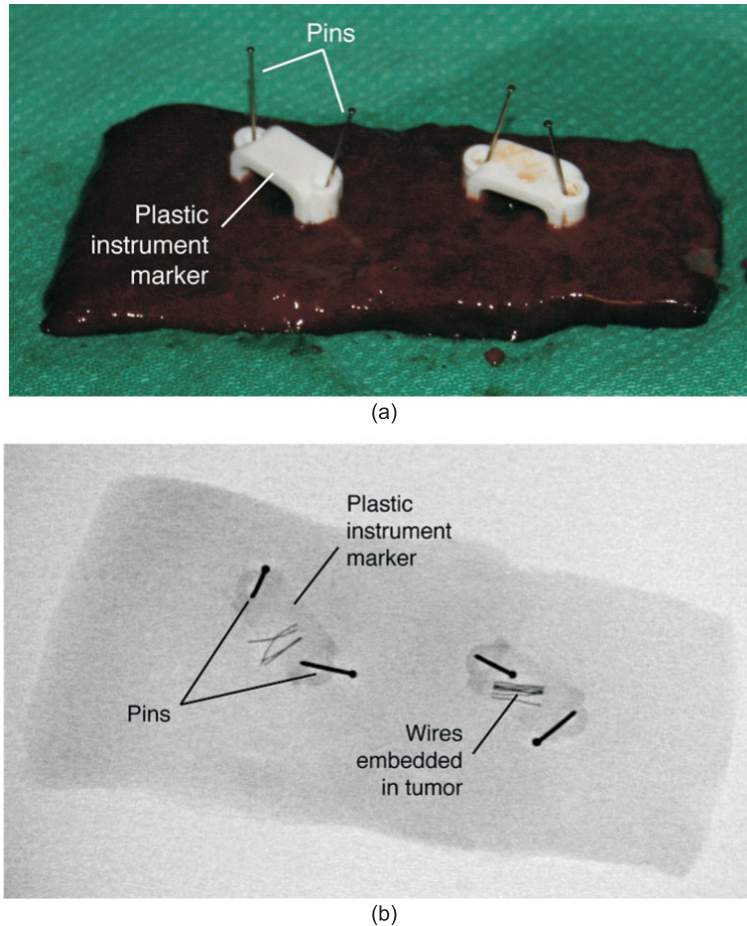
(a) Manually palpated tissue with each suspected tumor site marked by a plastic instrument marker held in place with two pins. (b) Radiograph of tissue, 10 mm tumors with embedded wire and plastic instrument markers.
